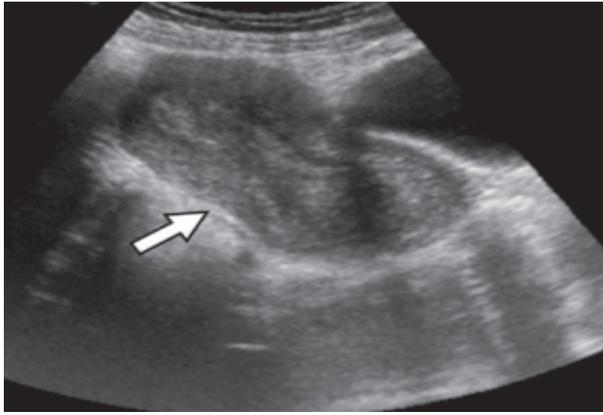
Transabdominal Ultrasound Showed Ballooned Cervix Containing Gestational Sac and Decidual Ring
